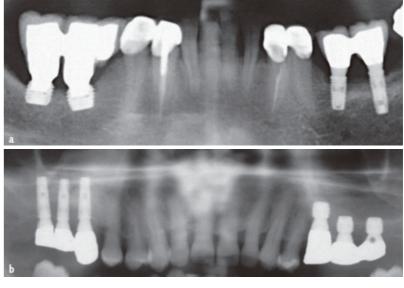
Panoramic radiographs of the same patients 1 year after prosthetic loading: a) mandible, b) maxilla
